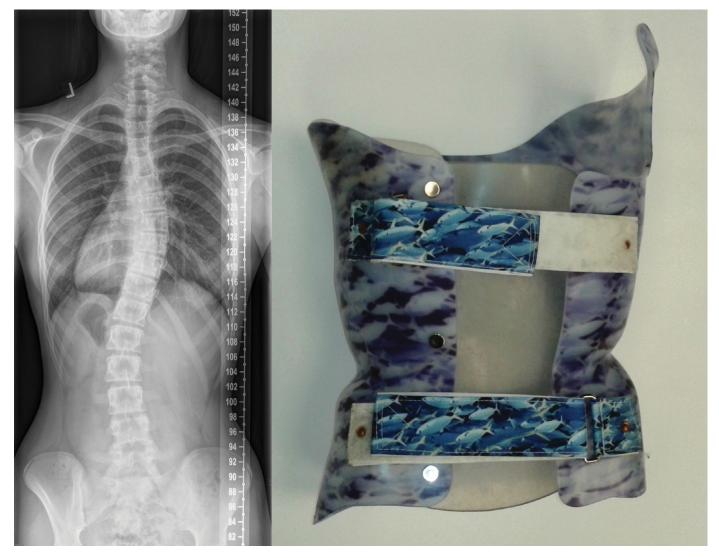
Radiograph of an AIS patient (left), and a scoliosis brace (right) intended to stop progression of the deformity.
